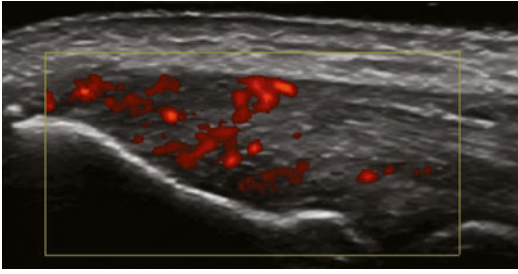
Power Doppler imaging demonstrates the presence of tendinous hyperaemia
